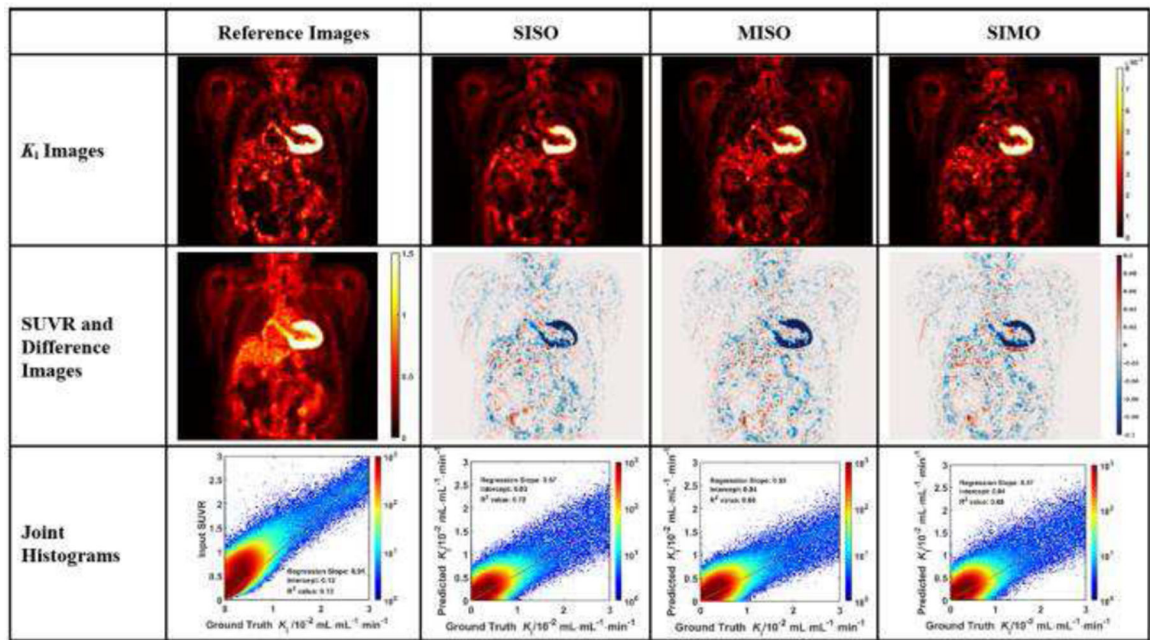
Evaluation analysis of sample subject #2 including the synthetic and reference K_i images, corresponding difference images, SUVR input image, and the joint histograms. In each joint histogram, the regression line was represented by the red straight line, with labels of regression slope, intercept and R^2 value.
